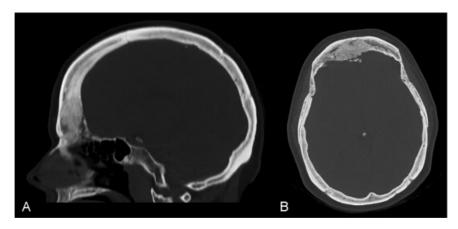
Preoperative (A) sagittal and (B) axial computed tomography scan demonstrating extensive bony involvement of the meningioma.
